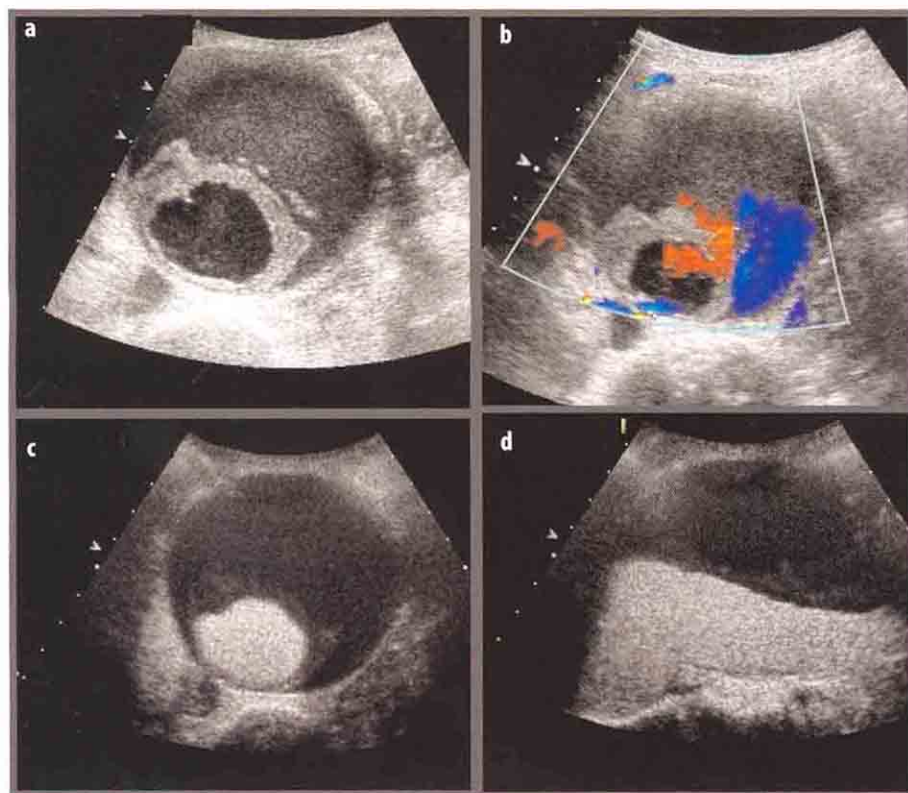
Large abdominal aortic aneurysm with inhomogeneous solid and fluid thrombus.* a, b Transverse and longitudinal US and CD scans of the aorta. An approximately 5 cm large abdominal aortic aneurysm is presented with a thin, irregular, hyperechoic thrombus, which is 2 cm thick, delimiting the flow chamber. There is a significant, *finely corpuscular, fluid component in the left antero-lateral region*, peripheral to the thin hyperechoic thrombus. The colour Doppler image of this fluid shows the presence of some sporadic colour signals (in blue). c, d Transverse and longitudinal CEUS scan of the aorta. The use of a contrast-specific harmonic algorithm performed at a low mechanical index nearly completely canceled out the signals derived from the stationary anatomic structures. Only minor signals from the thrombus remain (the thrombus is markedly hyperechoic in baseline US). Approximately 20 seconds after administration of the contrast medium, hyperechoic microbubbles appear and remain confined into the flow lumen delimited by the thin thrombus. No vascular phase shows signs of passage of the contrast medium into the fluid component of the thrombus
